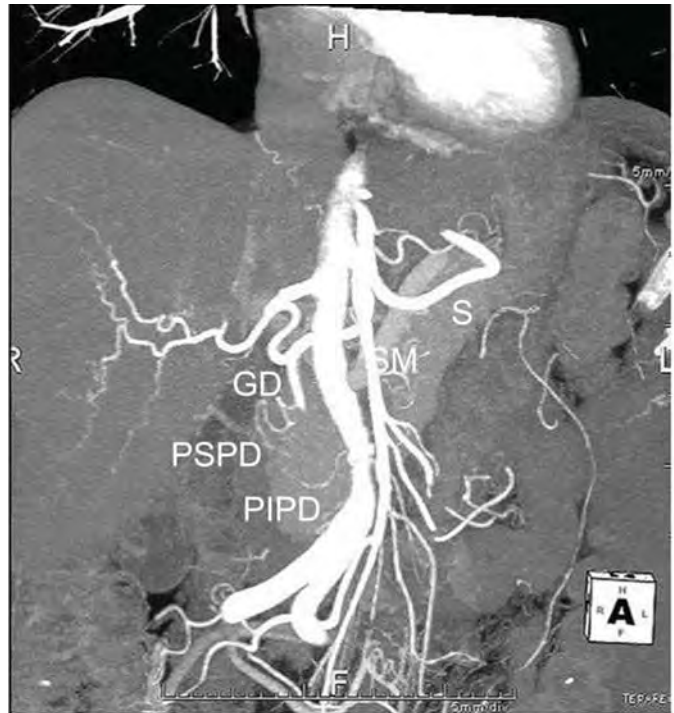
MIP reconstruction of a CT angiography, coronal view. SM mesenteric artery, S splenic artery, GD gastroduodenal artery, PSPD posterior superior pancreaticoduodenal artery, PIPD posterior inferior pancreaticoduodenal artery.
